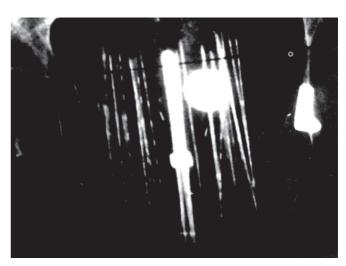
X-ray showing interstitial brachytherapy template with parametrial needles in situ (*Courtesy*: Dr BK Mohanty)
